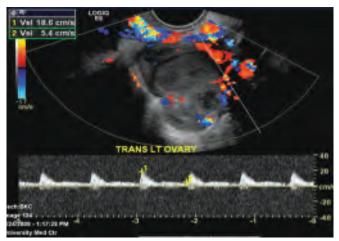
The same patient as in previous figure. Pulsed Doppler waveform analysis demonstrates moderate to high vascular impedance blood flow signals
